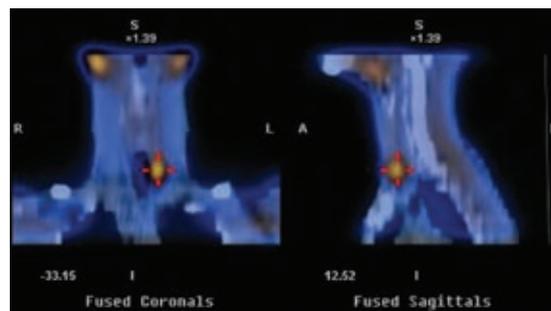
Fused SPECT-CT (fused single photon emission computed tomography and normal computed tomography) images of parathyroid adenoma. Such scans can improve spatial resolution, aiding tumour localisation and planning for surgery
